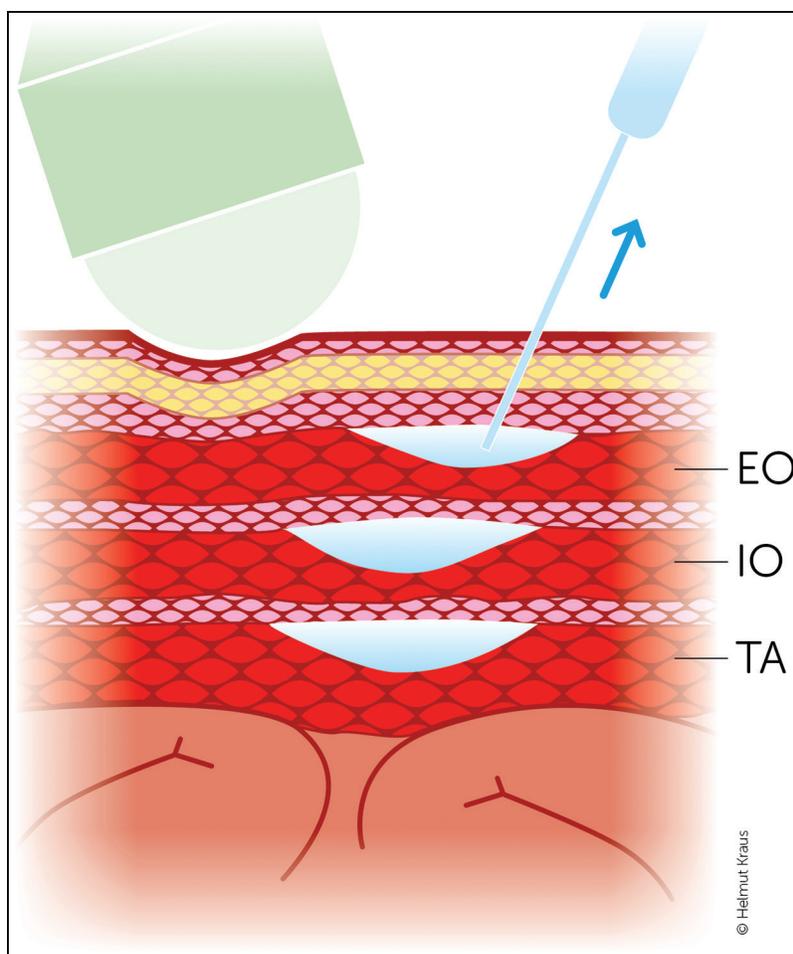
Injection of Botulinum Toxin A is performed under ultrasound guidance. The needle tip is advanced until it reaches the transversus abdominis muscle (TA), while pulling the needle slowly back, depots of Botulinum Toxin A are administered in all three muscle layers of the lateral abdominal wall: external oblique muscle (EO), internal oblique muscle (IO), and transversus abdominis muscle (TA)
